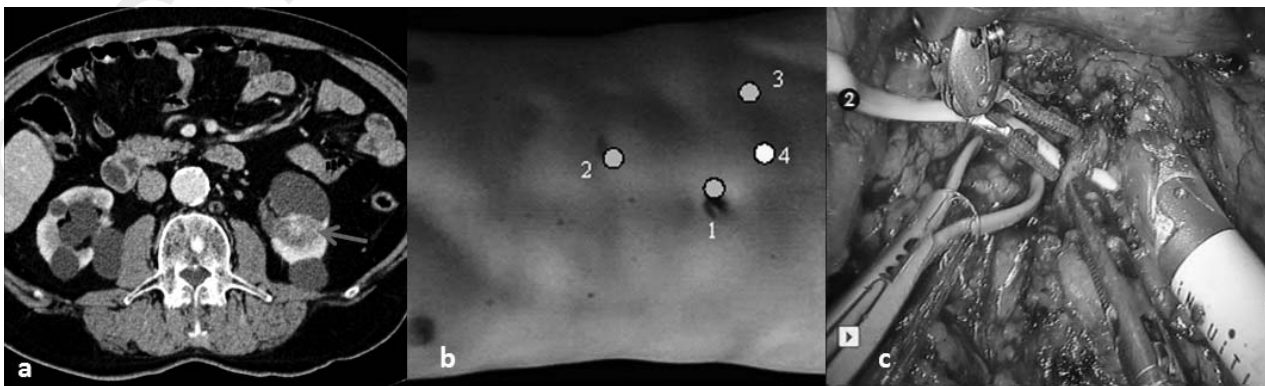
a) Preoperative CT scan showing the left kidney mass and bilateral renal cysts. b) Trocar position (1-2-3 robotic and 4th assistant port). c) Intraoperative picture showing the left main renal artery and the inferior polar artery encircled with a blue (dark grey) and yellow (light grey) vessel-loop respectively. The latter is clamped with a bulldog clamp.
